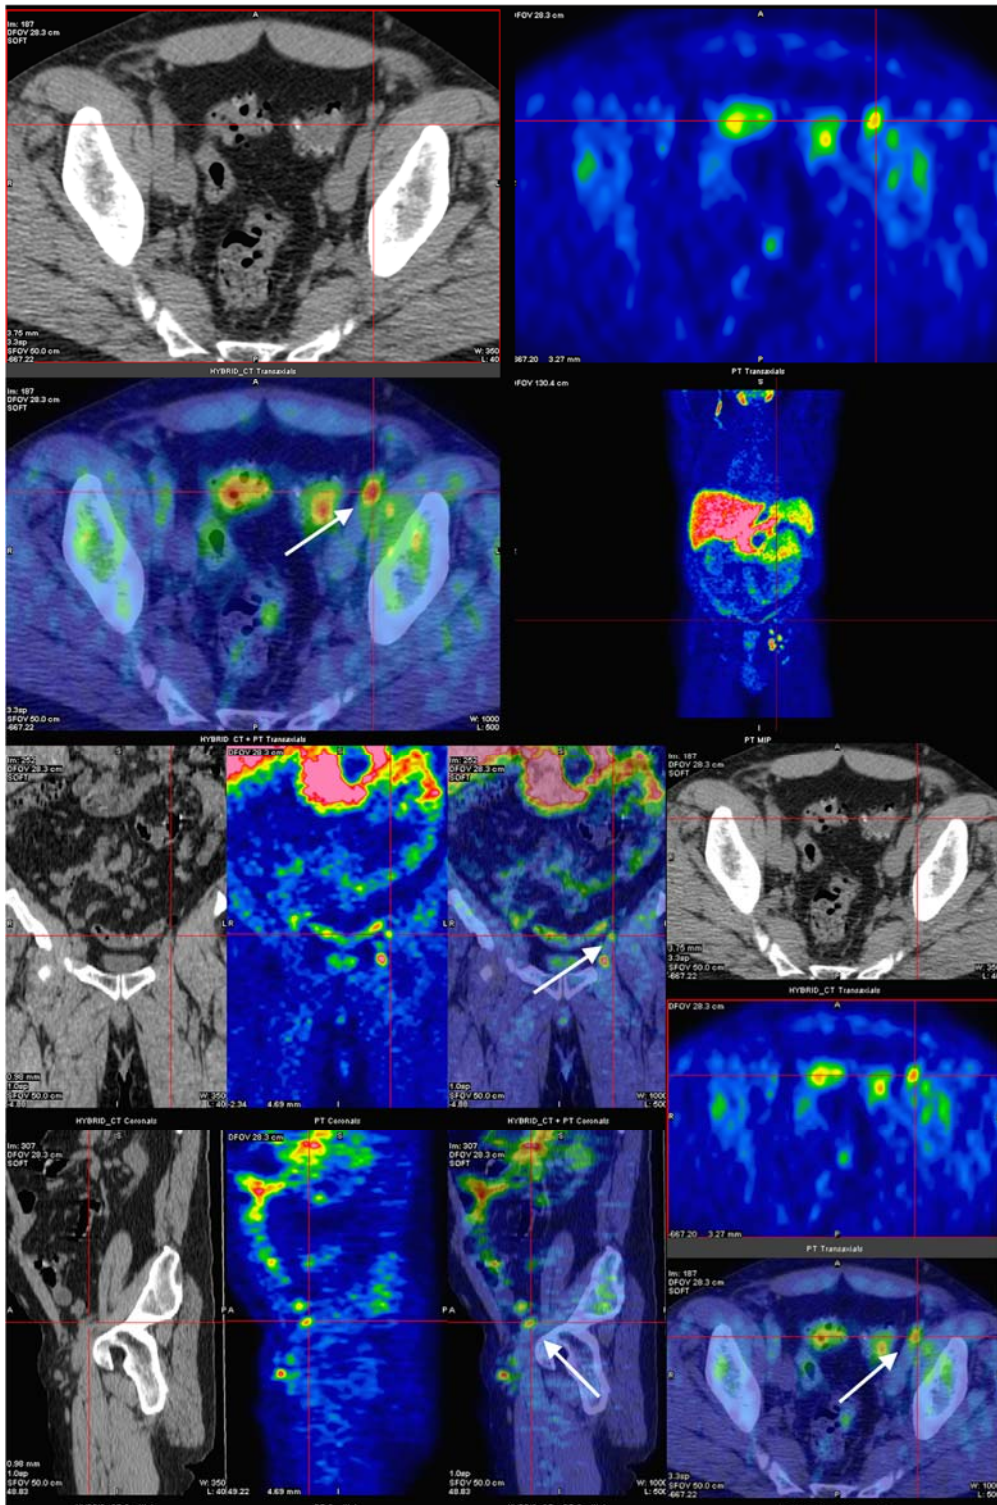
Fused PET/CTAC images showing ^{11}C -acetate uptake in a proximal left external iliac lymph node (white arrows) (SUV_{max} 3.39)
